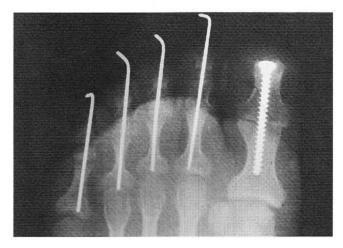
Dorsoplantar radiograph demonstrating hallux interphalangeal joint fusion and proximal interphalangeal joint fusions on digits 2, 3, 4 and arthroplasty with pinning of the 5th digit.
